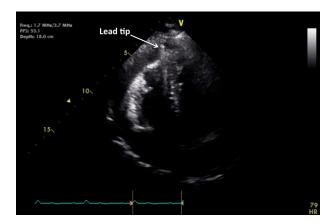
Video still of an apical 4-chamber view of the transthoracic echocardiogram of the case patient. Pericardial effusion is present along the right ventricle with the Durata lead tip visualized in the pericardial space, confirming perforation.
